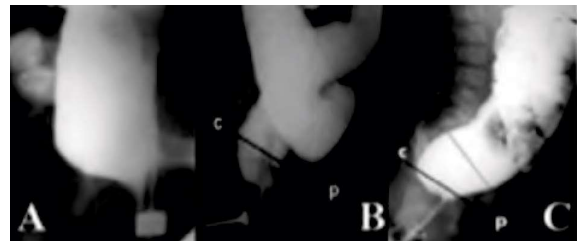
Radiographs of patients with ARM after surgery. A. After pull-through procedure. Megarectum combined with the lack of PRM action. There is efflux of barium outward from the anal canal. B. After posterior sagittal anorectoplasty. Sharp shortening of the anal canal indicates failure of the PRM. C. After anterior sagittal anorectoplasty. Megarectum in conjunction with the normal length of the anal canal.
